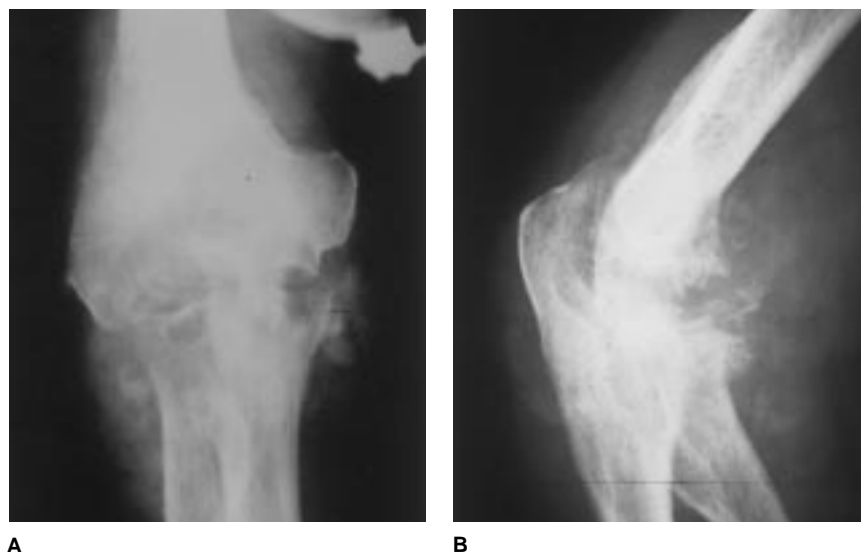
Anteroposterior (A) and lateral (B) radiographs of the elbow of a patient with syringomyelia depict destruction of the ulnohumeral and radiohumeral joints. Note the periarticular calcification and osteophyte formation.
